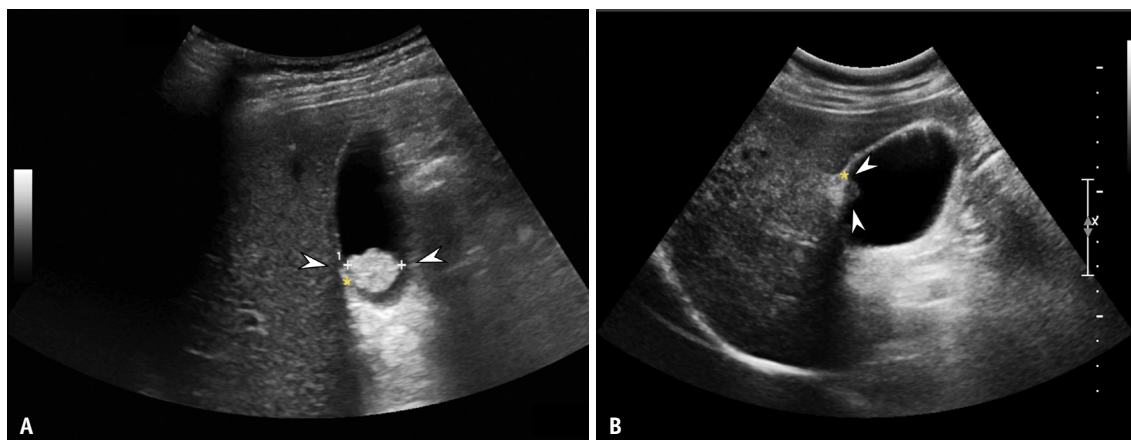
Measurement of the size of GBPs. A, B: The longest diameter should be confirmed across various ultrasound views. C, D: The size is measured from the outer margin to the outer margin of the pedunculated GBP in a 30-year-old woman. GBP = gallbladder polyp
